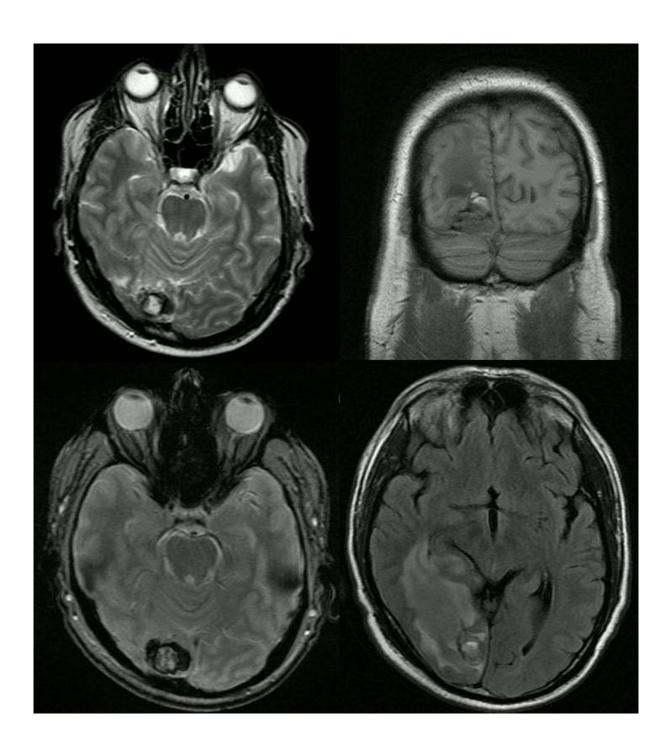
Preoperative MR scans. *Top left:* T2-weighted axial section. *Bottom left:* Axial section in gradient echo sequence. *Top right:* T1-weighted coronary section. *Bottom right:* Axial section in FLAIR sequence. A major oedema is discernible throughout the occipital lobe.
